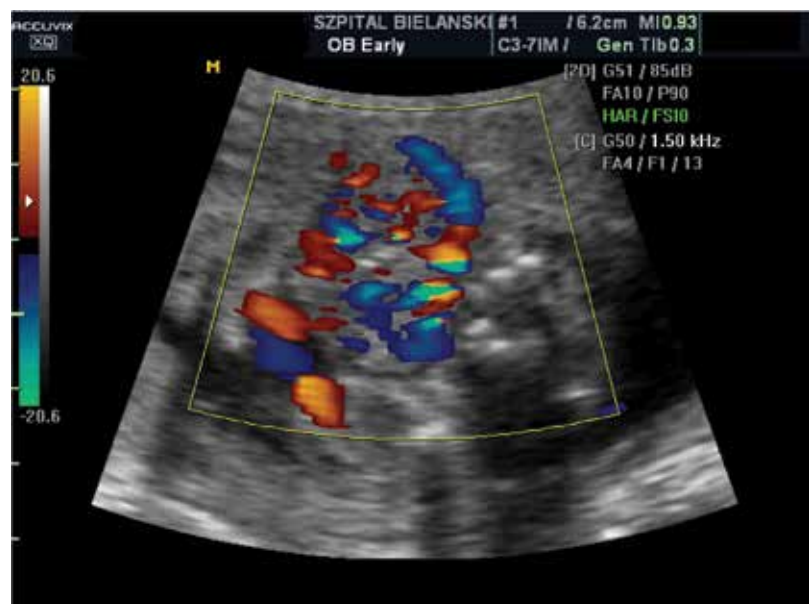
A. Foetal goitre, head hyperextension, and polyhydramnios at week 23 of gestation on longitudinal ultrasound scan; B. Foetal goitre at week 23 of gestation on transverse ultrasound scan; C. Foetal goitre with increased central blood flow at week 23 of gestation on colour Doppler examination
